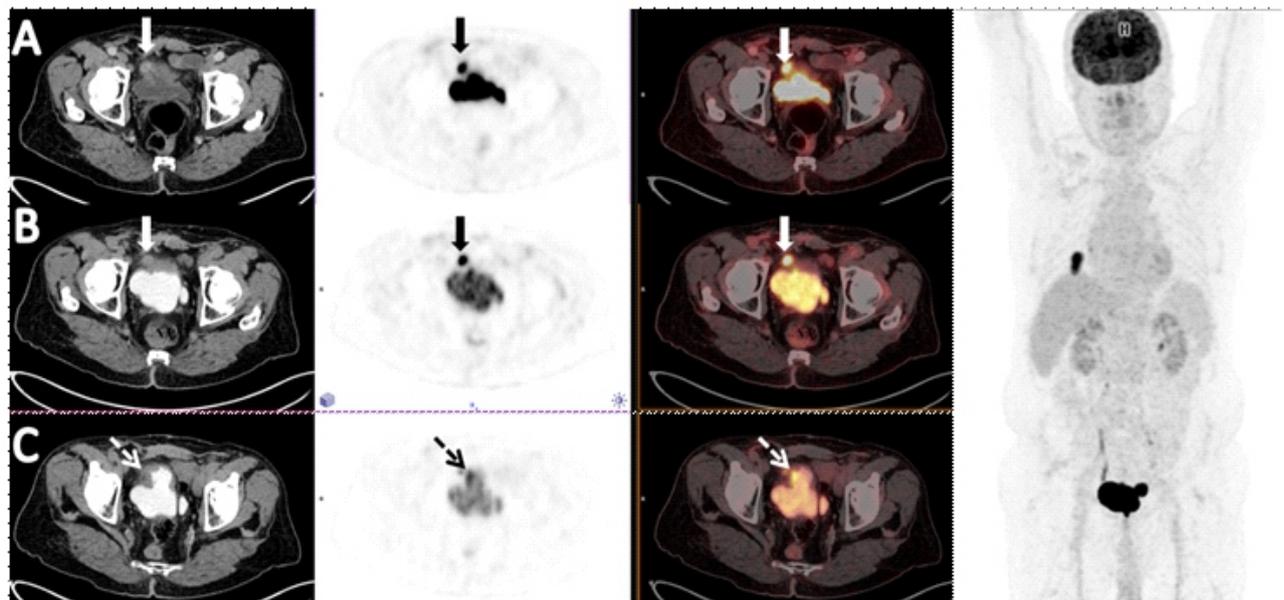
A 72-years-old man, who was diagnosed with urothelial carcinoma after TUR, underwent PET/CT imaging. While prevesical metastatic lymph node (arrows) is not clearly differentiated from the bladder walls in the first hour (early) images (A:CT-PET-Fusion images), it is clearly distinguished in the second hour (delayed) images (SUVmax:39.9) (B:CT-PET-Fusion images). While the primary tumor is not clearly differentiated in the early image, residual tumor tissue (dashed arrows) in the right anterolateral wall is clearly distinguished in the delayed images (C: CT-PET-Fusion images). Biopsy of the hypermetabolic nodular lesion (SUVmax:17.3) observed in the postero-basal segment of the right lung in the MIP image was reported as bladder cancer metastasis.
